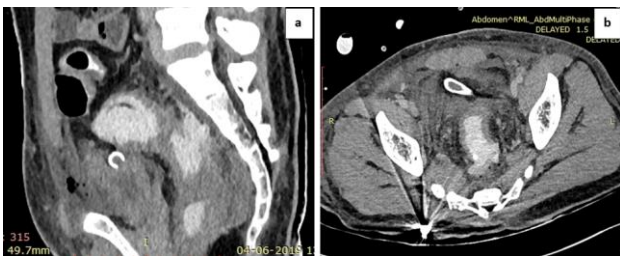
a) and b) Gunshot injury lower back with impacted bullet shows rectal injury: axial and sagittal reformatted CT of rectal wall discontinuity posteriorly with leakage of rectal contrast into the POD.
